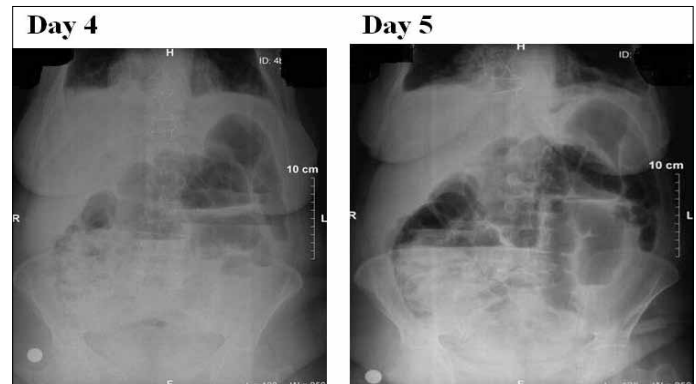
Sequential post-bypass abdominal X-ray on day 4 and 5. In this early period, no any of the radiological signs of massive bowel obstruction including a presence of multiple gas-fluid levels on supine radiographs are seen
